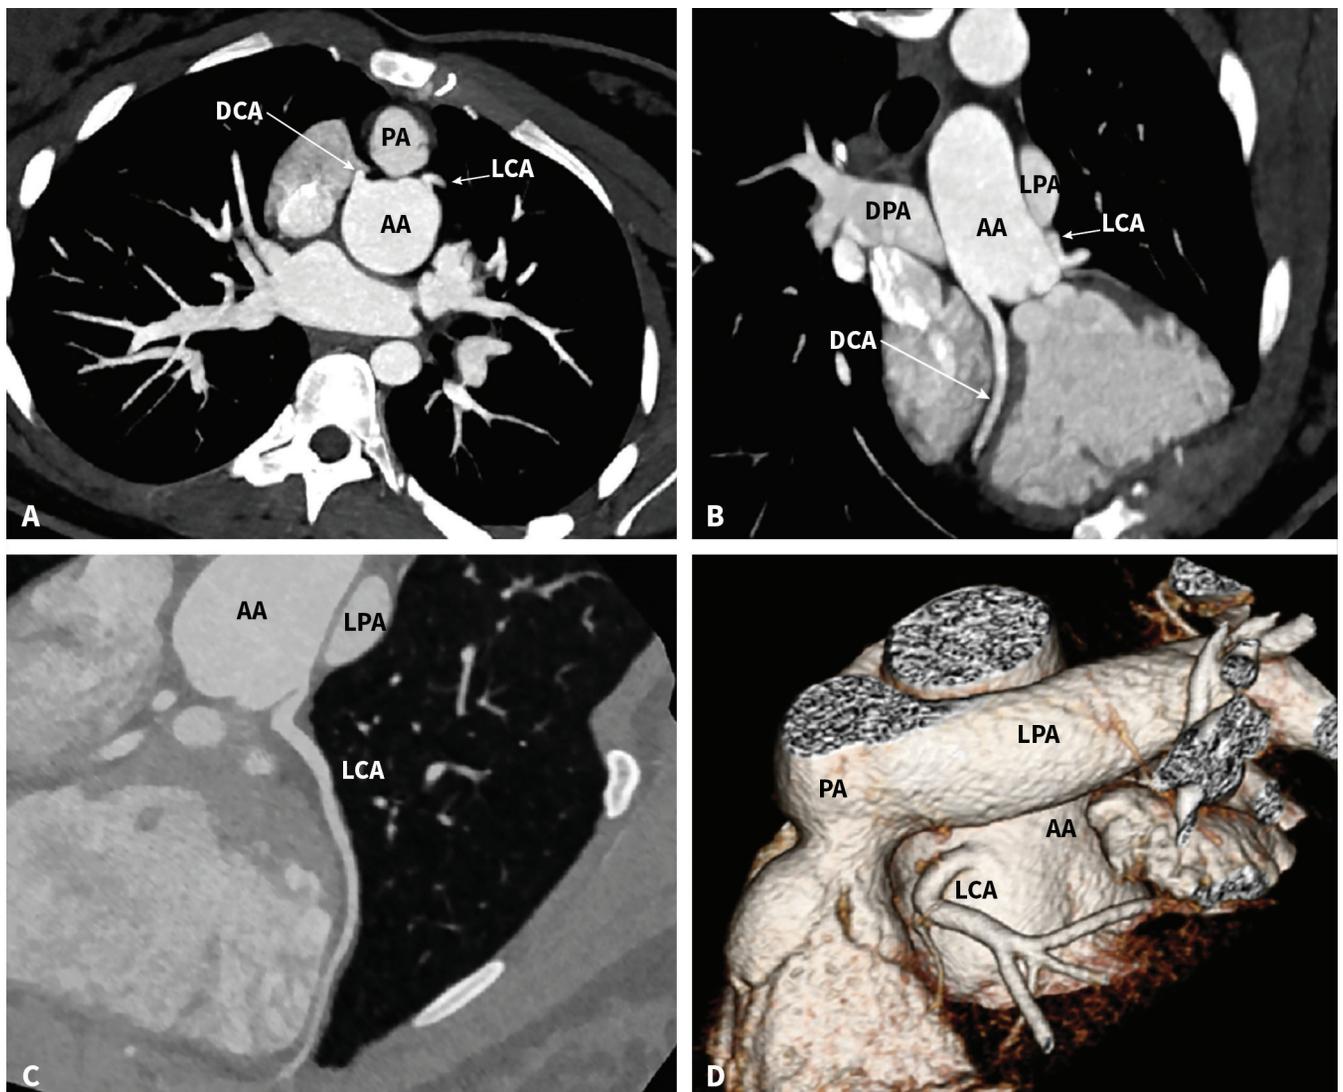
Computed tomography angiogram (CTA) after the arterial switch operation (ASO) in a patient with D-transposition of great arteries (D-TGA) - acute angle take-off of the anomalous left coronary artery, the initial part partly runs within the vessel wall.
